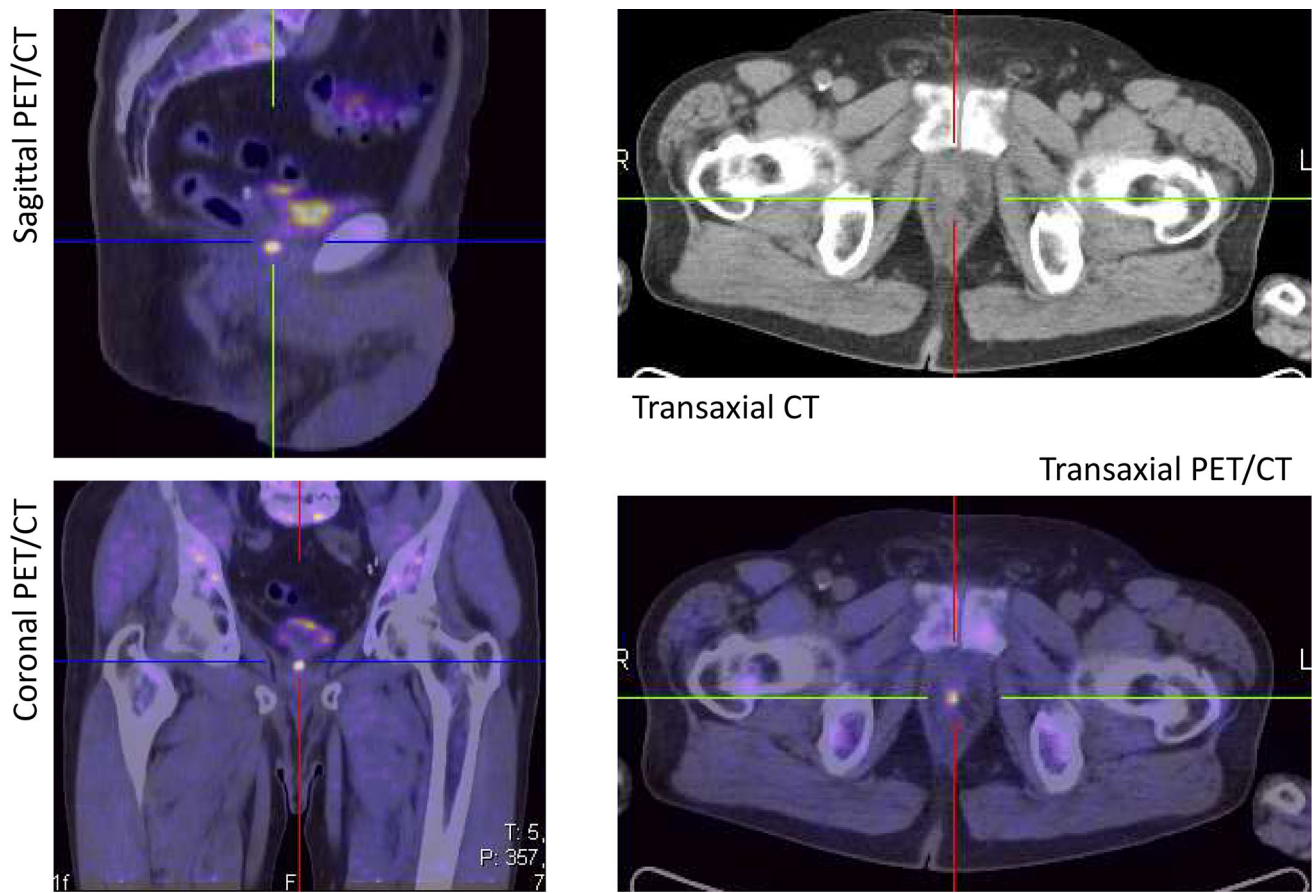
A 78-year-old patient with a focal FCH uptake in prostatic fossa after robotic radical prostatectomy, in proximity of urethra (GS = 7; PSA level 0.7 ng/mL) at PET/CT scan. The suspicion was not confirmed by biopsy.
